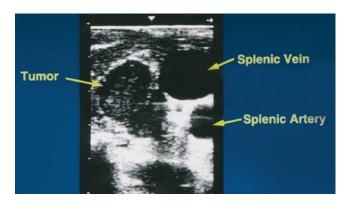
Intraoperative sonogram demonstrates the sharply marginated mass, which is predominantly hypoechoic and is situated in close proximity to the splenic vein and artery.
